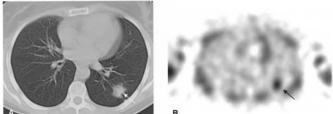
A 52-year-old female patient with a 20-mm adenocarcinoma in the lower lobe of the left lung which appeared as an SPN at CT (A, arrow). A focal area of increased <sup>99m</sup>Tc-tetrofosmin uptake, with a T/N value of 2.6, was evidenced at transaxial SPECT (B, arrow), corresponding to the carcinoma.
